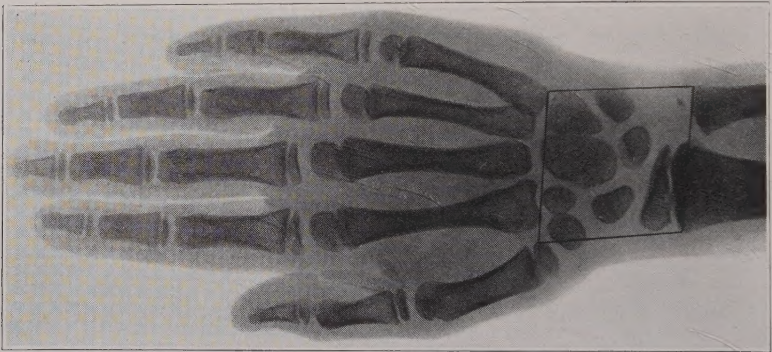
Roentgenogram of the hand of a girl 7 years and 5 months old, showing the outline of the area circumscribed for the Carter quadrilateral.
